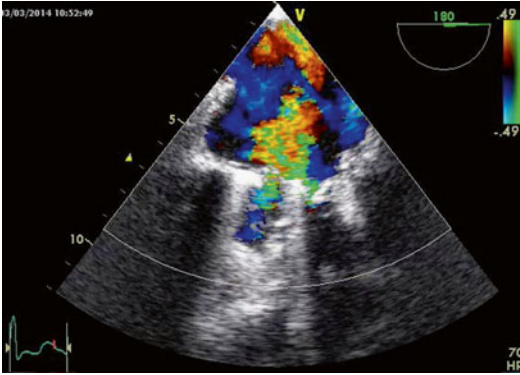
Transesophageal echocardiography showing the perivalvular leakage due to dehiscence of the prosthesis
